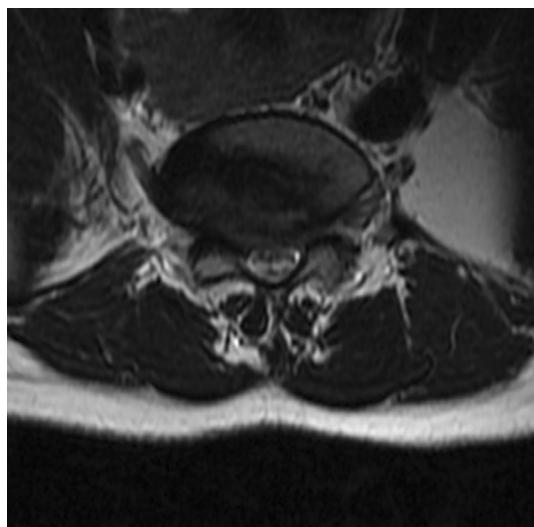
MRI T2-weighted Fast-Recovery Fast Spin-Echo (FRFSE) axial image of L5-S1 junction highlighting foraminal and canal stenosis. Reproduced with permission from the Children's Orthopaedic Center, Los Angeles
